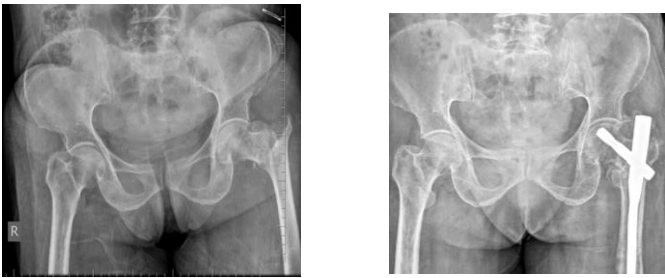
Preoperative and Postoperative X-ray with PFNA II
